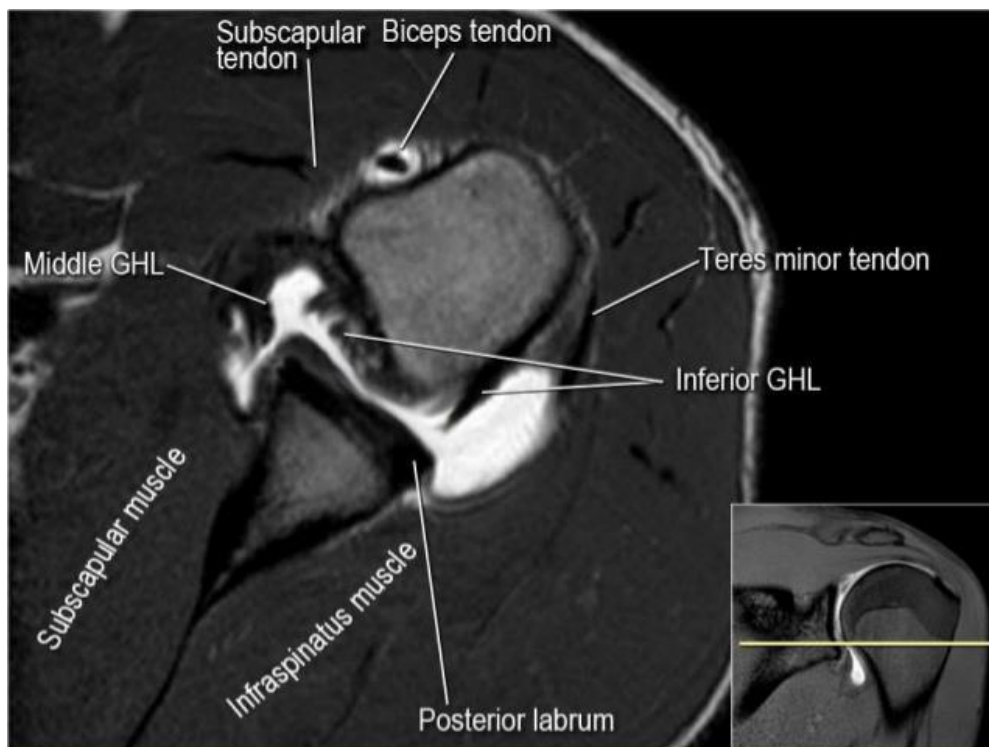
Axial view T2 weighted MRI of the shoulder showing the MGHL and IGHL.
